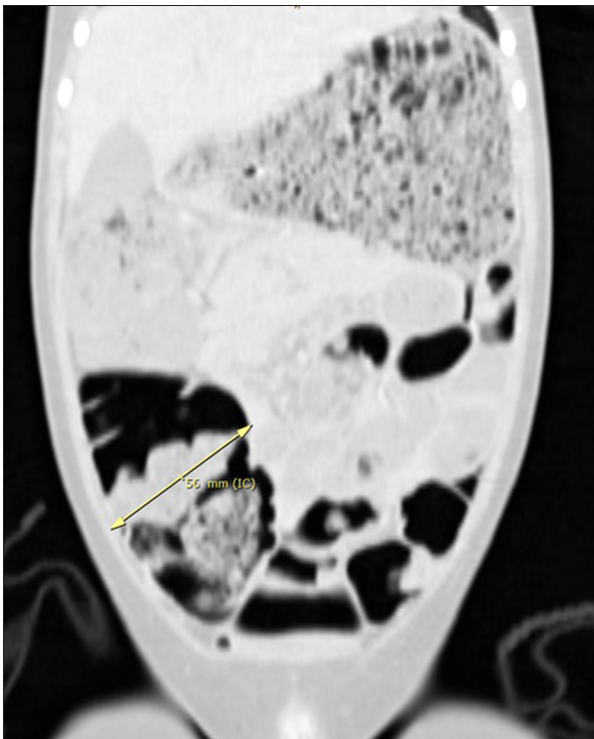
Abdominal CT with important gastric dilatation with material inside and intestinal distension.
